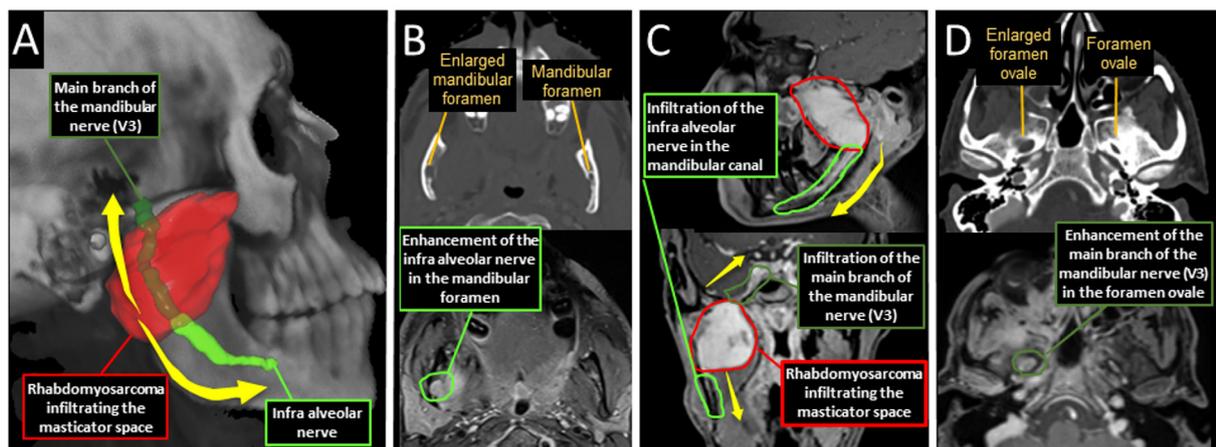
Rhabdomyosarcoma infiltrating the masticator space with macroscopic PNI of branches of the mandibular nerve (V3). (A) 3D overview of the extension pathways (yellow arrows) along the main branch of the mandibular nerve (through the foramen ovale) in a retrograde manner, and along the inferior alveolar (in the mandibular canal) in an anterograde manner. (B) Note enlargement of the mandibular foramen on CT-scan, and corresponding enhancing lesion on post Gado T1-weighted MRI. (C) Sagittal and coronal views of post Gado T1-weighted MRI of the different nerve extension pathways. (D) Note enlargement of the foramen ovale on CT-scan, and corresponding enhancing lesion on post Gado T1-weighted MRI. Abbreviations. PNI: perineural invasion; CT: computed tomography; Gado: gadolinium; MRI (magnetic resonance imaging).
